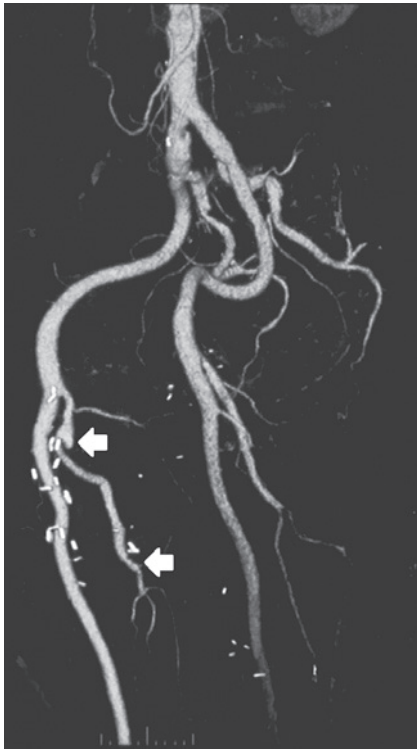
Postoperative 3-dimensional computed tomography shows a patent saphenous vein graft (white arrows).
